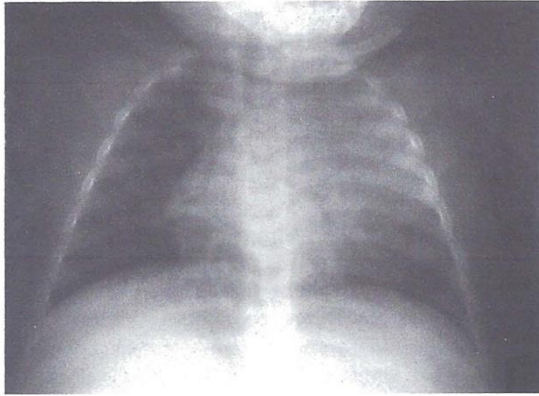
Chest radiograph demonstrating the compression of the left main bronchus by enlarged tuberculous lymph nodes. Alveolar consolidation is visible in the left upper lobe.
